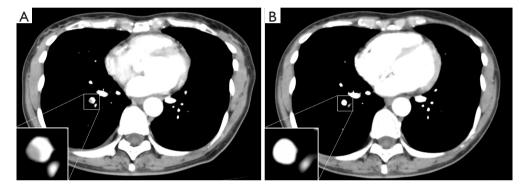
Enhanced chest CT images. (A) An intraluminal filling defect in the right lower lobe artery (insert) (6 weeks after the first HRCT); (B) the right lower lobe artery without filling defect (insert) (three months after the introduction of anti-coagulant therapy).
